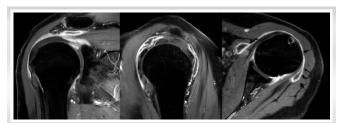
T2-STIR sequence of the left shoulder MRI. It displays distention of the subacromial-subdeltoid and subcoracoid bursas with associated synovial hypertrophy, and intense synovial enhancement.
